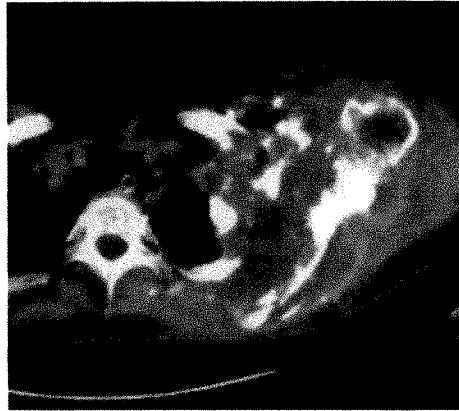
Osteosarcoma of right clavicle in 39-year-old man 11 years after radiation therapy for Hodgkin disease. CT scan shows destruction of medial end of right clavicle with an associated soft-tissue mass.
